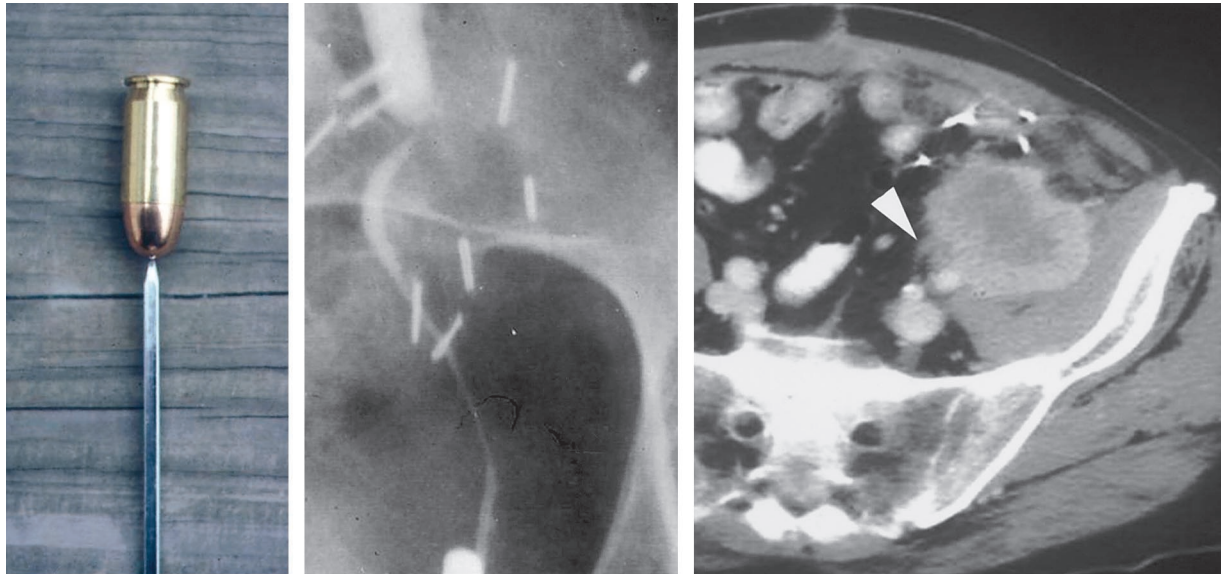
(a) Bullet on a bodkin. (b) Retrograde ureteropyelogram demonstrates an abrupt transition between the dilated upper ureter and normal-appearing lower ureter. (c) Enhanced CT scan demonstrates encasement of the ureter (arrowhead) in the left anatomic pelvis by a mass, secondary to recurrent carcinoma of the colon.
